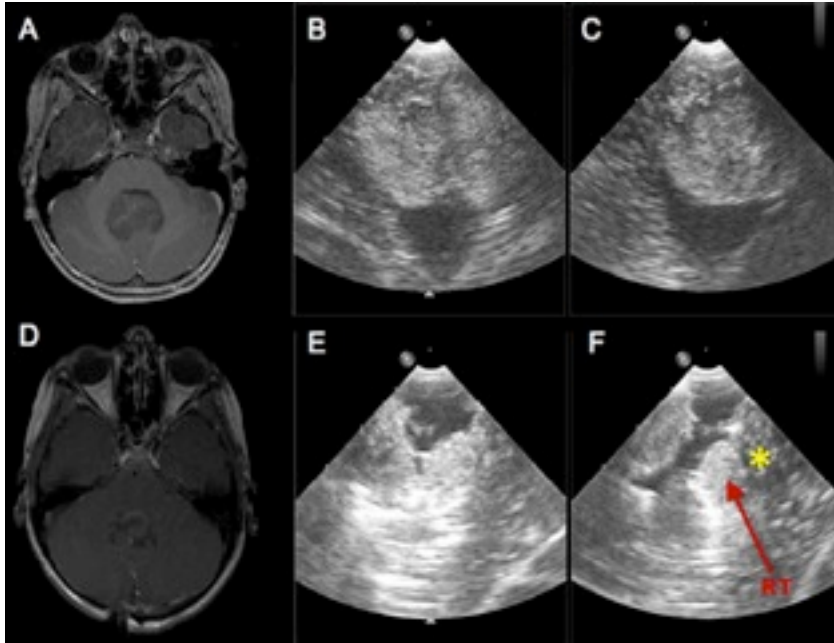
Preoperative axial T1 MRI with contrast (A) of a 9-year old female with a medulloblastoma in the 4th ventricle and the corresponding “X-Plane” 3D IOUS images in “X- Plane” mode as shown in coronar (B) and sagittal (C) planes before tumor removal. Total removal was intended by the surgeon but was not confirmed by the neuroradiologist. On the post-operative axial T1 MRI with contrast (D), a small residual was seen (left to the asterisk) corresponding to the IOUS in coronar (E) and sagittal (F) planes. RT Residual tumor
